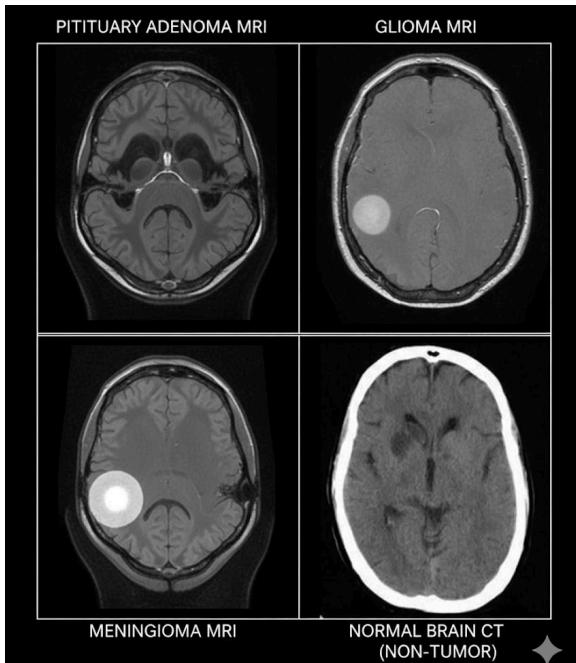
Sample MRI images for each tumour class.
